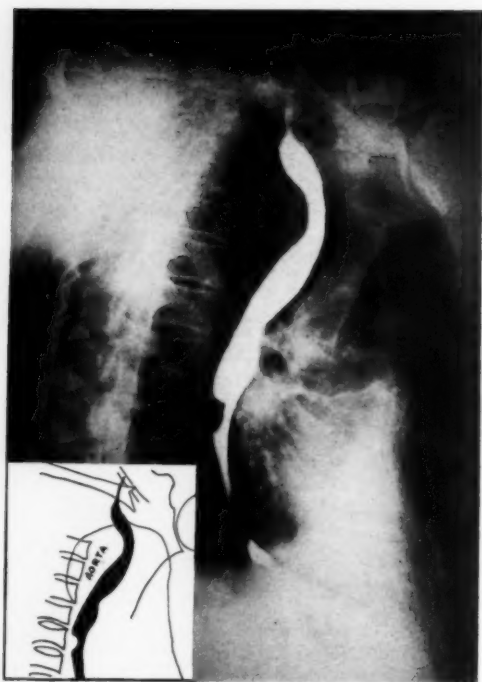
Right oblique roentgenogram showing anterior displacement of esophagus.
